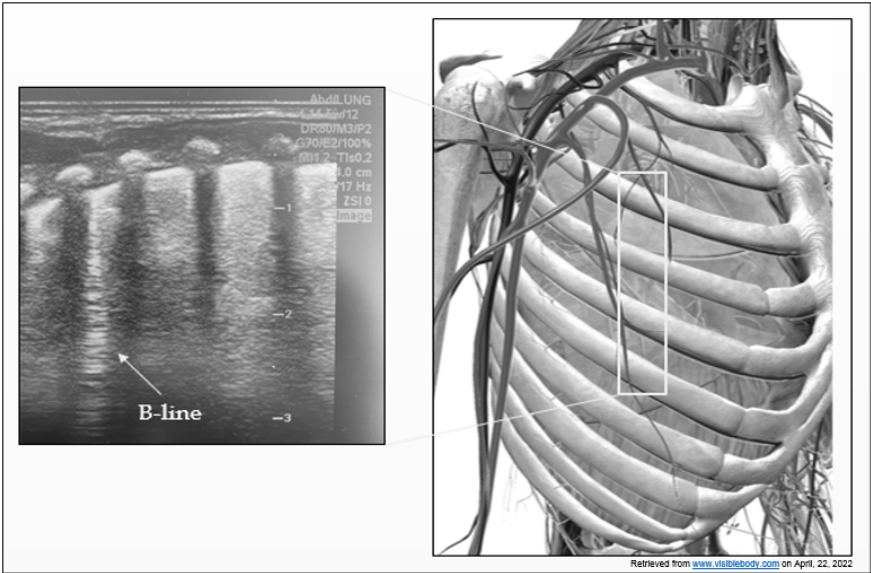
Lung ultrasound.
